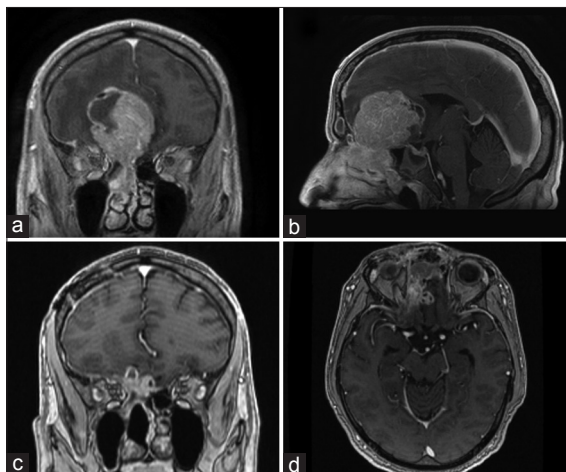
Postcontrast MRI post-contrast with AP (a) and sagittal (b) images showing enhancing lesion extending from nasal sinus to anterior cranial fossa with frontal lobe invasion. Post-operative postcontrast MRI post-contrast shows Axial axial (c) and AP (d) views with near total resection of mass
